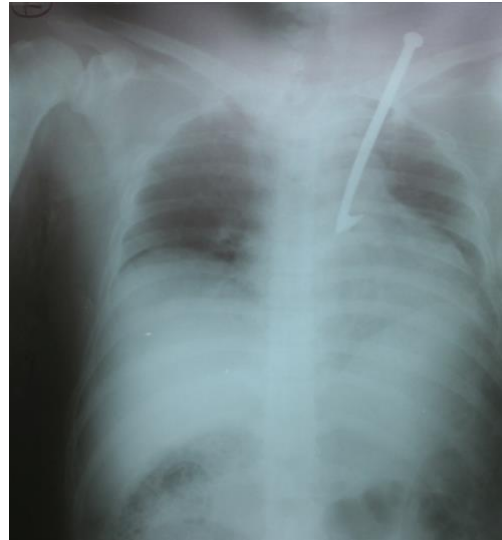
Chest radiograph showed the steel shaft of the flying feather had penetrated his heart.
